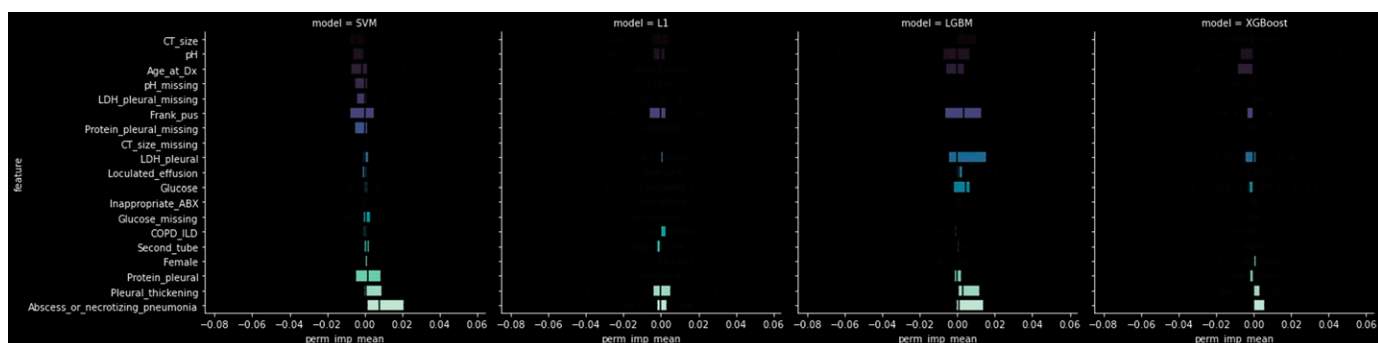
Ranked variable importance from each machine learning model (Note: the most important ranking variables rank from bottom to top). ABX = antibiotics; COPD = chronic obstructive pulmonary disease; CT = computed tomography; Dx = diagnosis; ILD = interstitial lung disease; L1 = L1-penalized logistic regression; LDH = lactate dehydrogenase; LGBM = light gradient-boosting machine; SVM = support vector machine; XGBoost = extreme gradient boosting.
